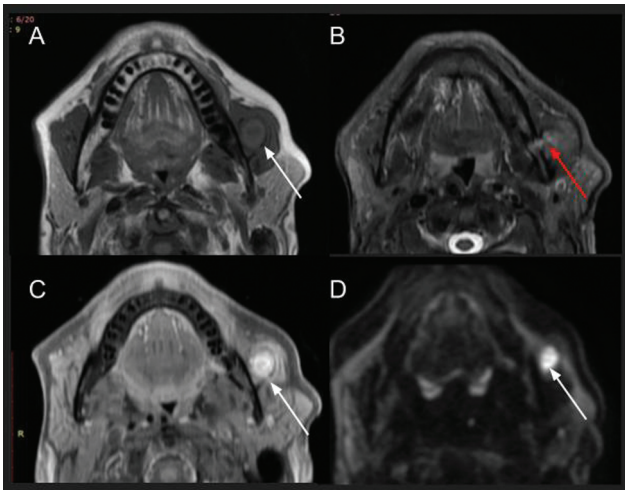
Bacterial osteomyelitis of the mandible. A 43-year-old male patient presented with an ulcer with discharge for 4 months. Magnetic resonance imaging (MRI) shows ill-defined T1 hypointense (A) and short tau inversion recovery (STIR) hyperintense (B) marrow involvement of left hemimandible with cortical breach and sinus formation (red arrows) extending to adjacent masticator space causing masseteric abscess (white arrows) showing postcontrast enhancement (C) and diffusion restriction (D).
